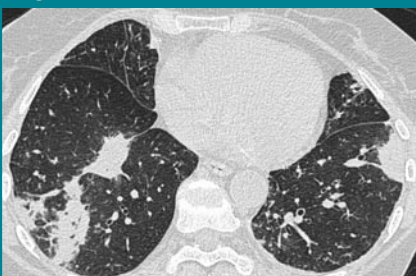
Transverse CT scan shows multifocal consolidation.
